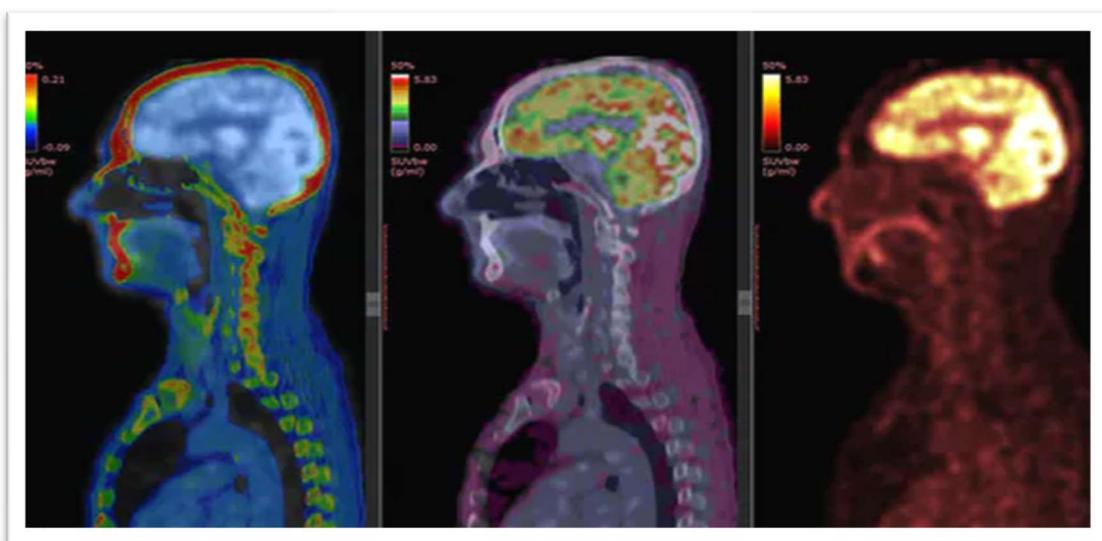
Nuclear imaging, PET scan overlaid with MRI scan
